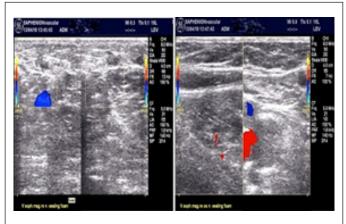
Ultrasound after sealing micro-foam therapy of GSV
